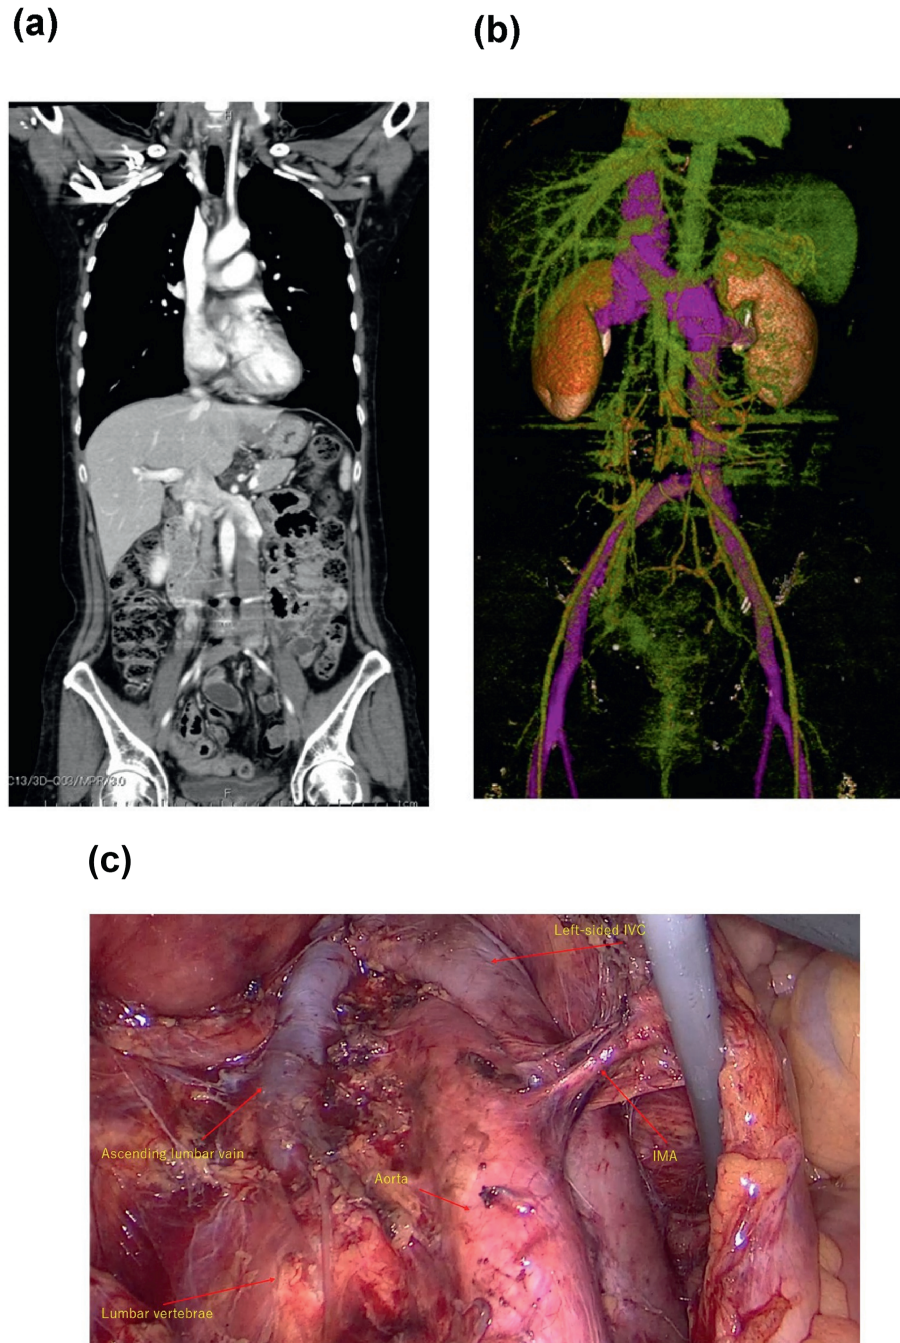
(a) Contrast-enhanced computed tomography image showing a left-sided inferior vena cava (IVC). (b) Three-dimensional computed tomography image showing a left-sided IVC. (c) The left-sided inferior vena cava crosses the abdominal aorta, and the ascending lumbar vein flows into its right side.
